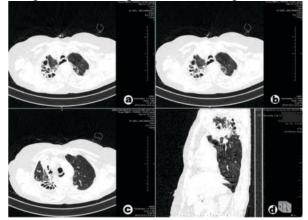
&b – Axial and coronal HRCT images of a 49-yearold female showing the cavitation on apicoposterior segment of left upper lobe with surrounding consolidation and GGO. Figure 6c&d – Axial and sagittal HRCT images of 49-year-old
